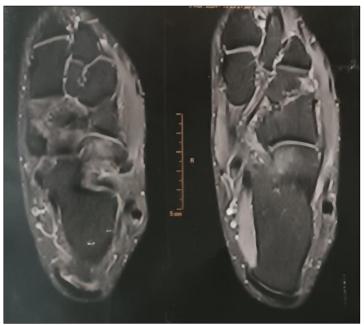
T2 axial MRI of the soft tissue lesion on the dorsal foot showing a heterogeneous lesion and slightly hyperintense
